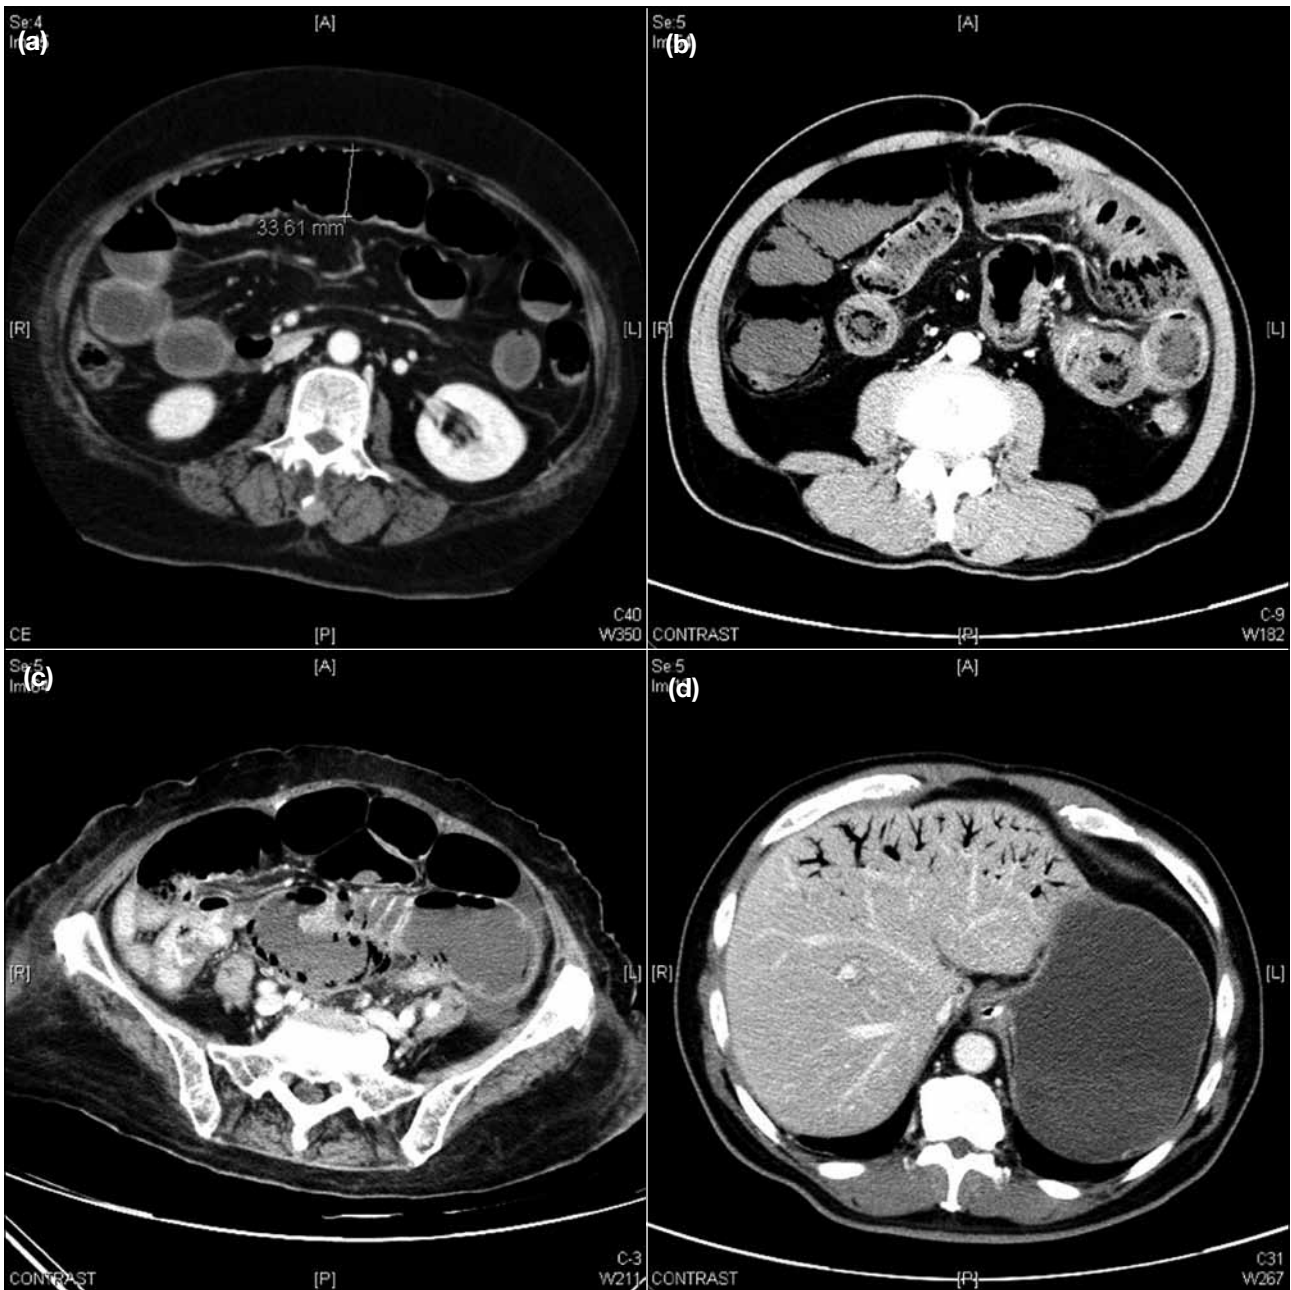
Axial contrast computed tomography scans show (a) small bowel dilatation and thin wall in the dilated segment, (b) mural hypoenhancement and pneumatosis intestinalis, (c) pneumatosis intestinalis, and (d) portal venous gas.
